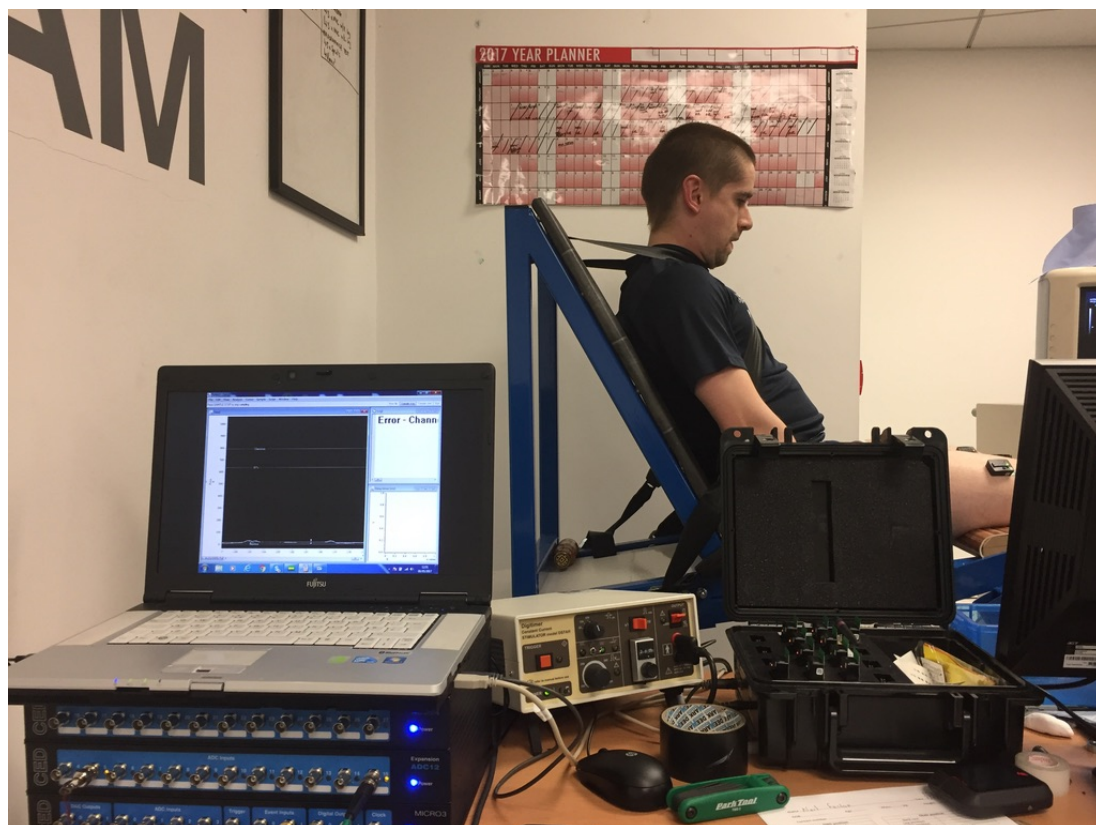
Investigators point of view when carrying out muscle function testing in final experimental data collection of surface EMG, electronic stimulator and custom-built dynamometer. Ultrasound machine in background of right photo
